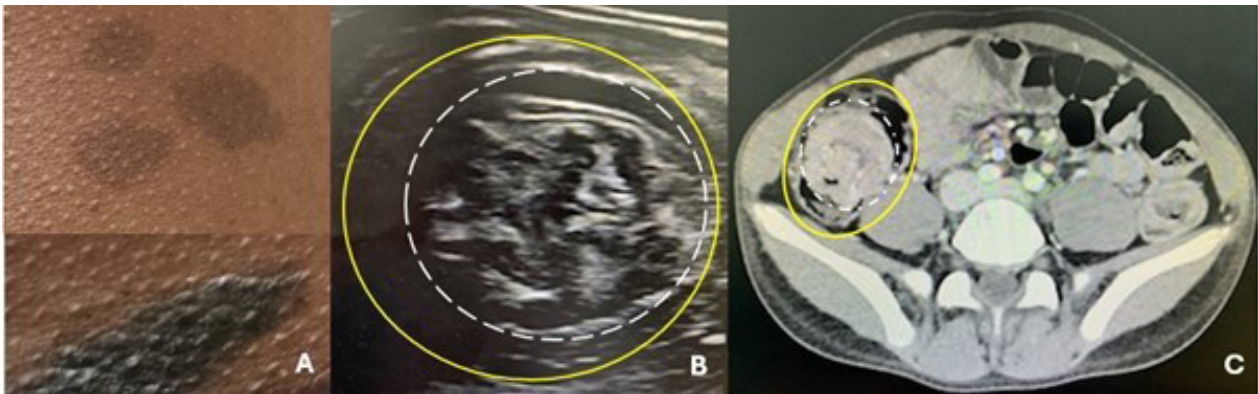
A) Café-au-lait spots. B) Abdominal ultrasound demonstrating a hypoechoic edematous outer loop of bowel (yellow ellipse) and a hyperechoic compressed loop of bowel telescoping within (dotted white ellipse), C) and CT scan confirming the diagnosis of colo-colic intussusception.
